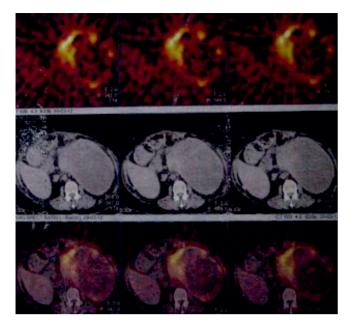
Ring shaped contrast enhancement on 123-I MIBG scintigram.
